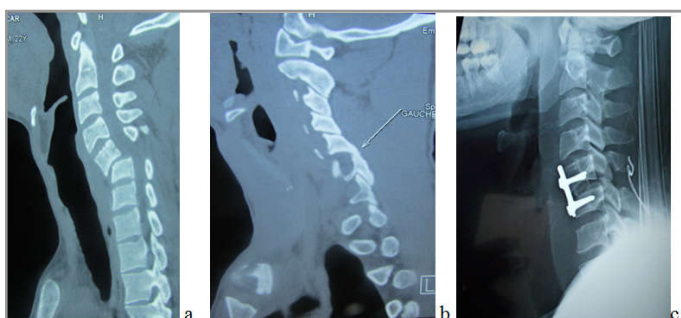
cervical spine CT scan, sagittal view showing neglected C5-C6 fracture dislocation (a) with joint fusion (arrow) (b), postoperative imaging control (c)
